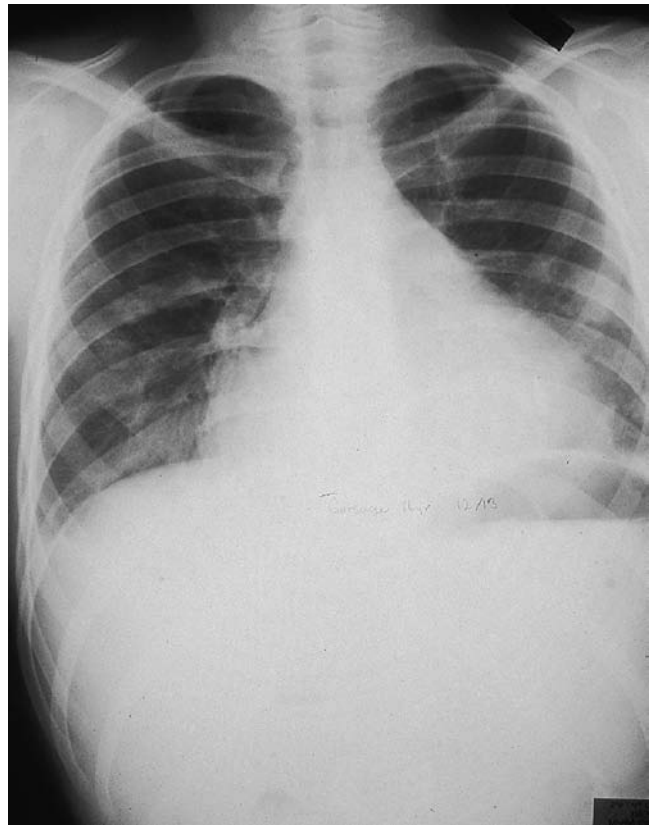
A 16-year-old boy had a steel bar strike him in the chest. Initially, he was hemodynamically stable but had muffled heart sounds. The patient quickly decompensated and required emergent pericardiocentesis after the chest radiograph. In the operating room, the patient was noted to have a small epicardial laceration on the surface of the heart.
